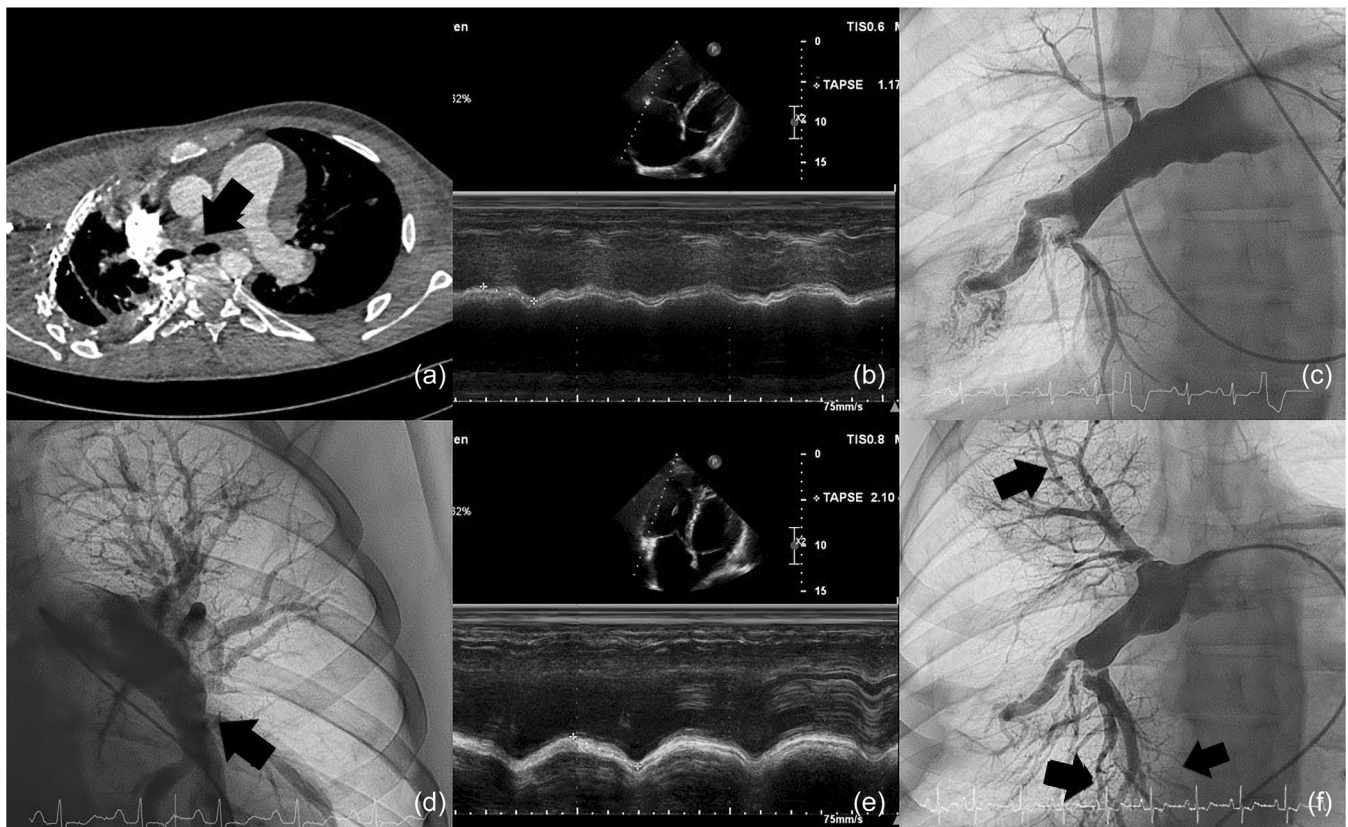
(a) Computed tomography angiography—the arrow indicates fibrotic changes in proximal part of the right pulmonary artery (RPA). (b) Transthoracic heart ultrasonography shows impaired right ventricular contractility with the decrease in tricuspid annular plane systolic excursion (TAPSE). (c) Baseline pulmonary arteriography of the RPA shows massive perfusion defects (posteroanterior view). (d) Baseline pulmonary arteriography of the left pulmonary artery (LPA) the arrow shows honeycomb-like perfusion defect in the segmental branch of LPA (posteroanterior view). (e) Transthoracic heart ultrasonography after levosimendan infusion shows significant increase in TAPSE. (f) Pulmonary arteriography of RPA after the third balloon pulmonary angioplasty session—arrows show significant perfusion improvement in superior and inferior lobes (posteroanterior view).
